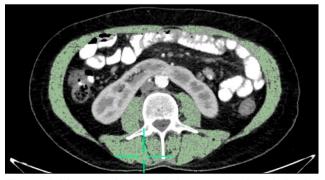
Axial computed tomography image crossing from the level of the third lumbar vertebrae of the gastric cancer patient. Skeletal muscle (green) was measured by using the OsiriX software semi-automatically.
